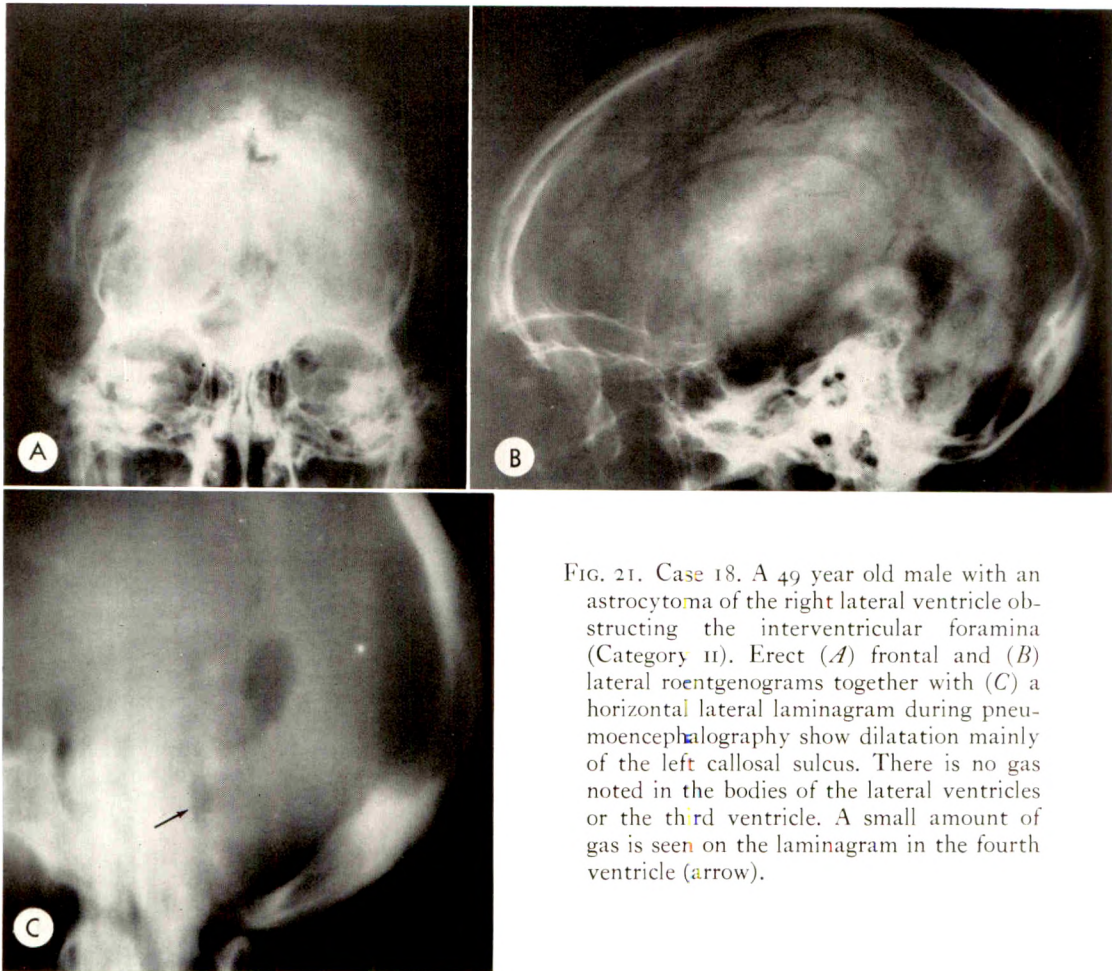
Case 18. A 49 year old male with an astrocytoma of the right lateral ventricle obstructing the interventricular foramina (Category II). Erect (A) frontal and (B) lateral roentgenograms together with (C) a horizontal lateral laminagram during pneumoencephalography show dilatation mainly of the left callosal sulcus. There is no gas noted in the bodies of the lateral ventricles or the third ventricle. A small amount of gas is seen on the laminagram in the fourth ventricle (arrow).
